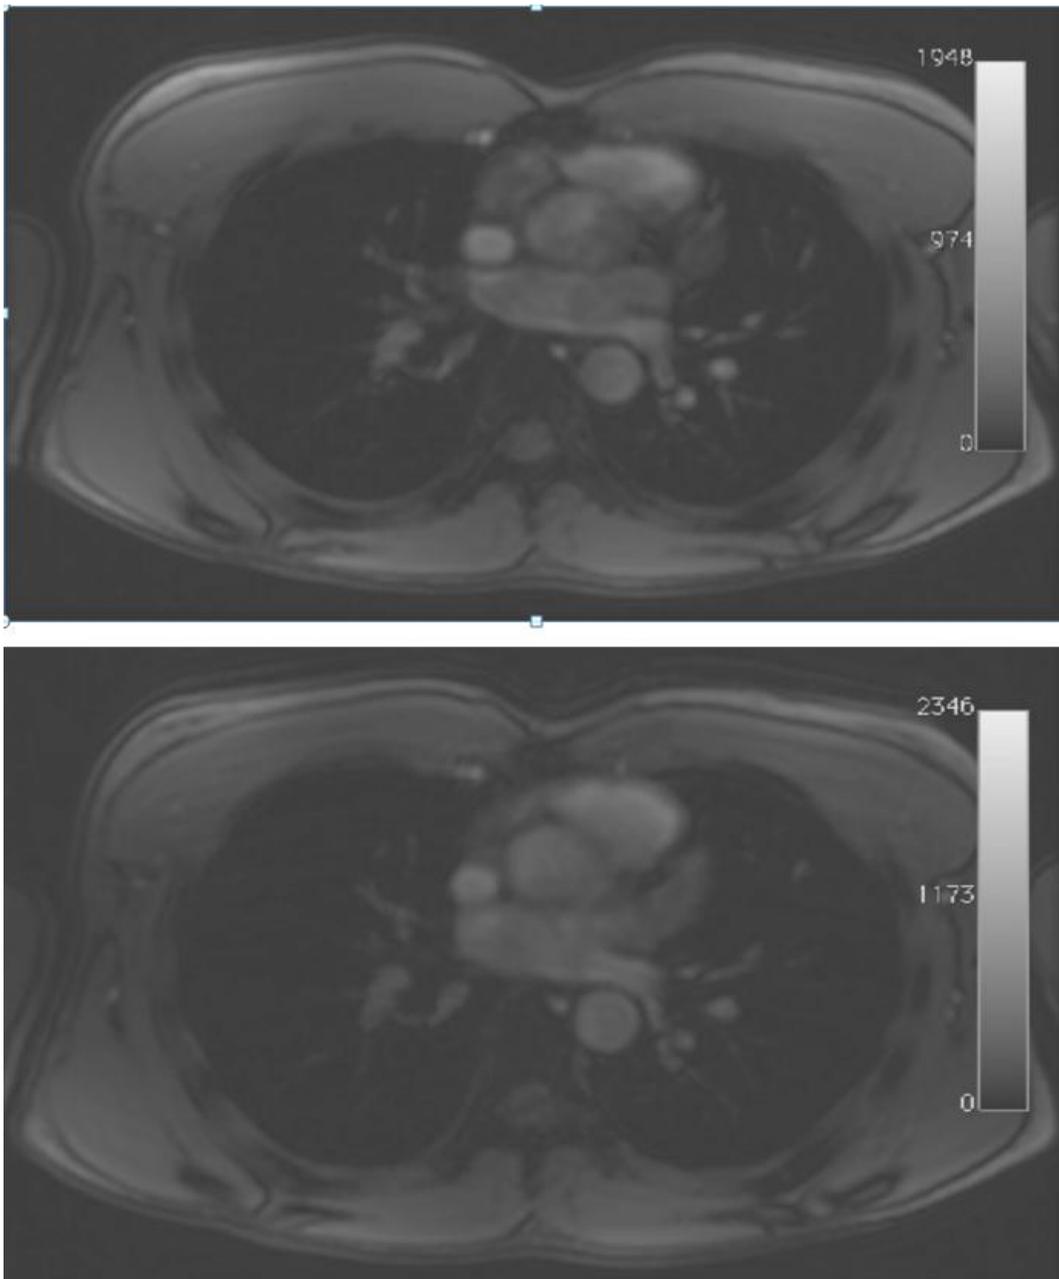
Images acquired during MRI scan. Top shows image quality while subject is at rest, and bottom shows image quality while subject is exercising in bore (images acquired during MRI scan). It is clear in the bottom image that exercise caused more noise and other artifacts to appear in the image. Nevertheless, data from this image was successfully obtained and analyzed.
